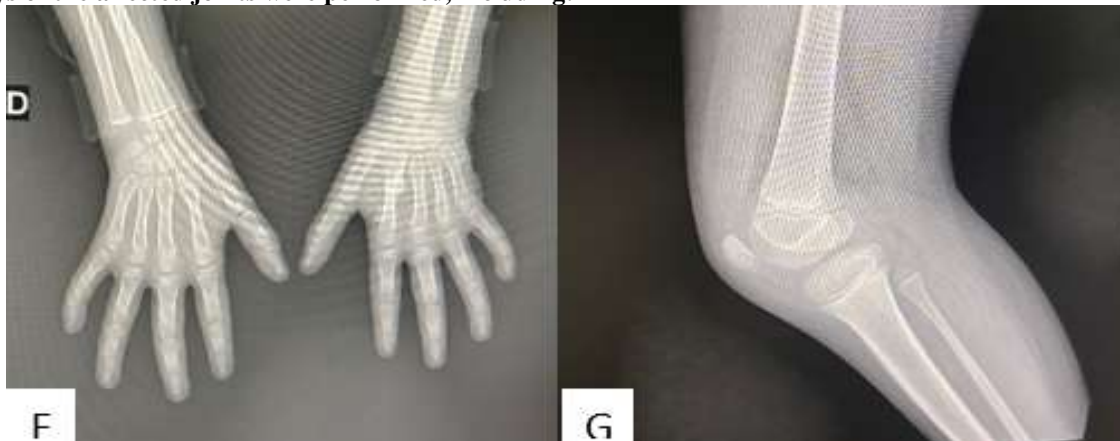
X-ray of the front hands showing pinching of the joint lines (F) X-ray of the knee in profile showing the presence of an effusion in the right knee.
